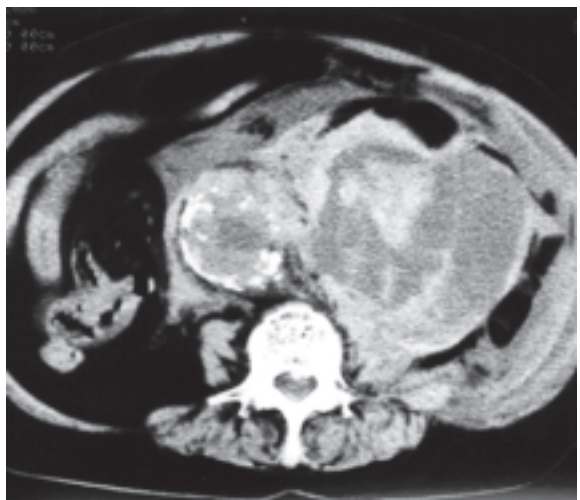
Haemorrhagic involvement of the psoas muscle in a 70-year-old man with a ruptured abdominal aortic aneurysm. Unenhanced axial CT scan shows a large retroperitoneal haematoma extending from the aortic aneurysm. Calcification of the aortic wall is present. There are areas of high attenuation within the haematoma, indicating fresh blood.
